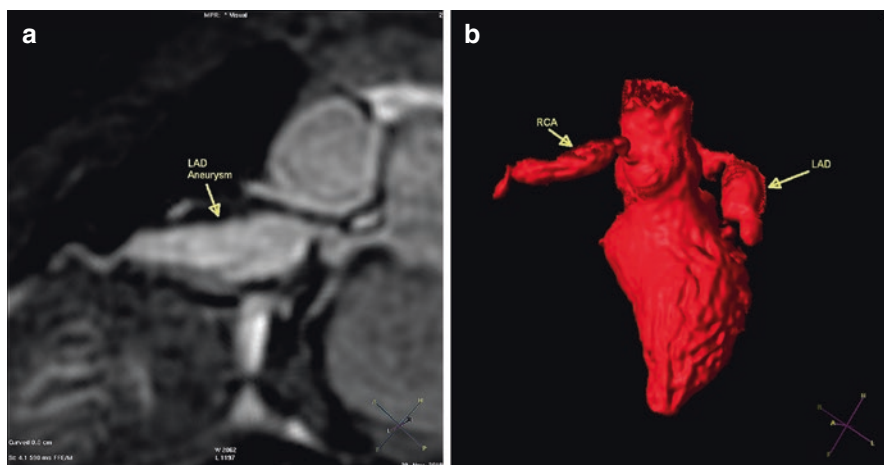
(a) Cardiac MRI of a patient with multiplanar reconstruction showing severe aneurysm of left anterior descending (LAD) coronary artery; (b) Multiplanar 3D reconstruction of same patient with diffuse aneurysms of LAD and right coronary artery
